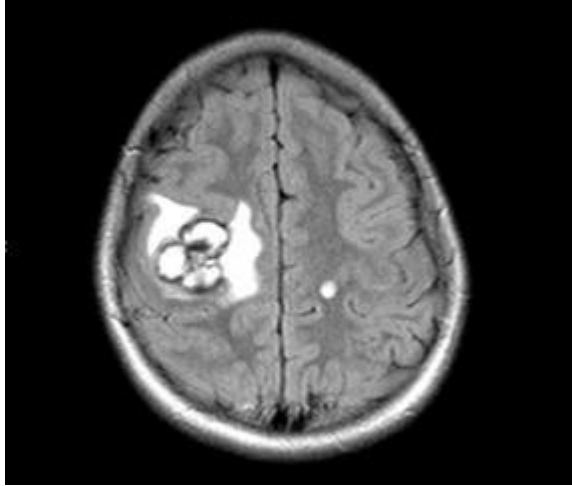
Initial brain MRI T2 flair with contrast image of bilateral cavernomas.
